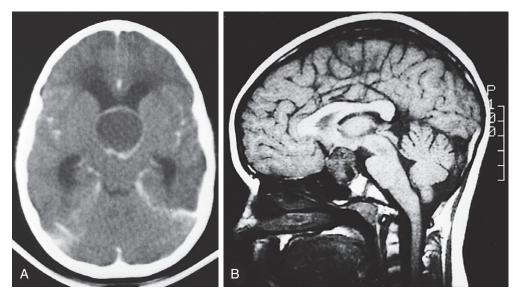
Craniopharyngioma. A, CT scan shows a large, spherical suprasellar mass, obliteration of the third ventricle, and associated hydrocephalus. B, MRI scan provides superior visualization of the anatomic relationship of this tumor with the optic chiasm and hypothalamus. (Courtesy Department of Neuroradiology, University Health Center of Pittsburgh, Pittsburgh, Pa.)
